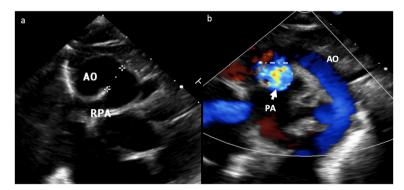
a: 2D-Echo in a modified suprasternal view showing aortopulmonary window. b: 2D-Echo in a modified suprasternal view with colour Doppler. AO, aorta; PA, pulmonary artery; RPA, right pulmonary artery.
